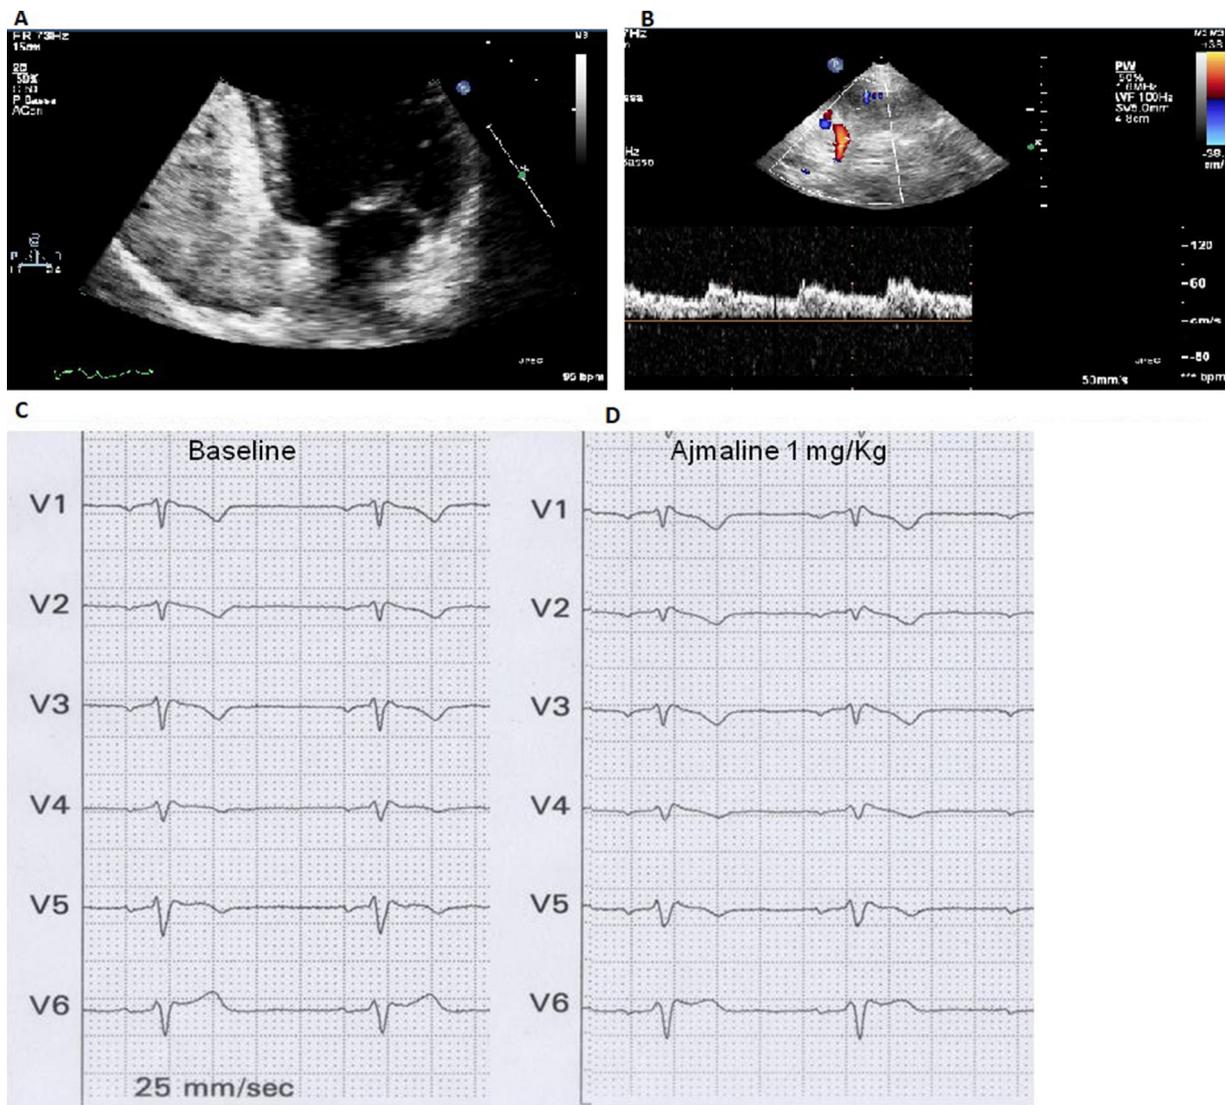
(A) Apical 4-chamber view after intravenous contrast administration: microbubbles are not visualised in the left side of the heart; (B) Transcranial Doppler study of intracranial middle cerebral artery after intravenous contrast administration do not show microembolic signals; (C) Right precordial leads placed in the II° (V1–V2), III° (V3–V4) and IV° (V5–V6) intercostal space at baseline and (D) after infusion of ajmaline 1 mg/kg in 5 min.
